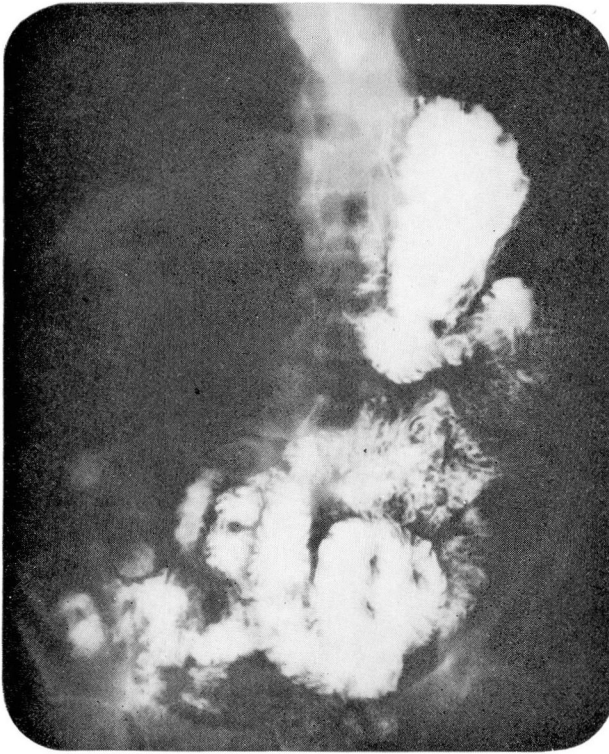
A roentgenogram from the postgastroscopy gastrointestinal series showing a normal gastric remnant and efferent loop.
